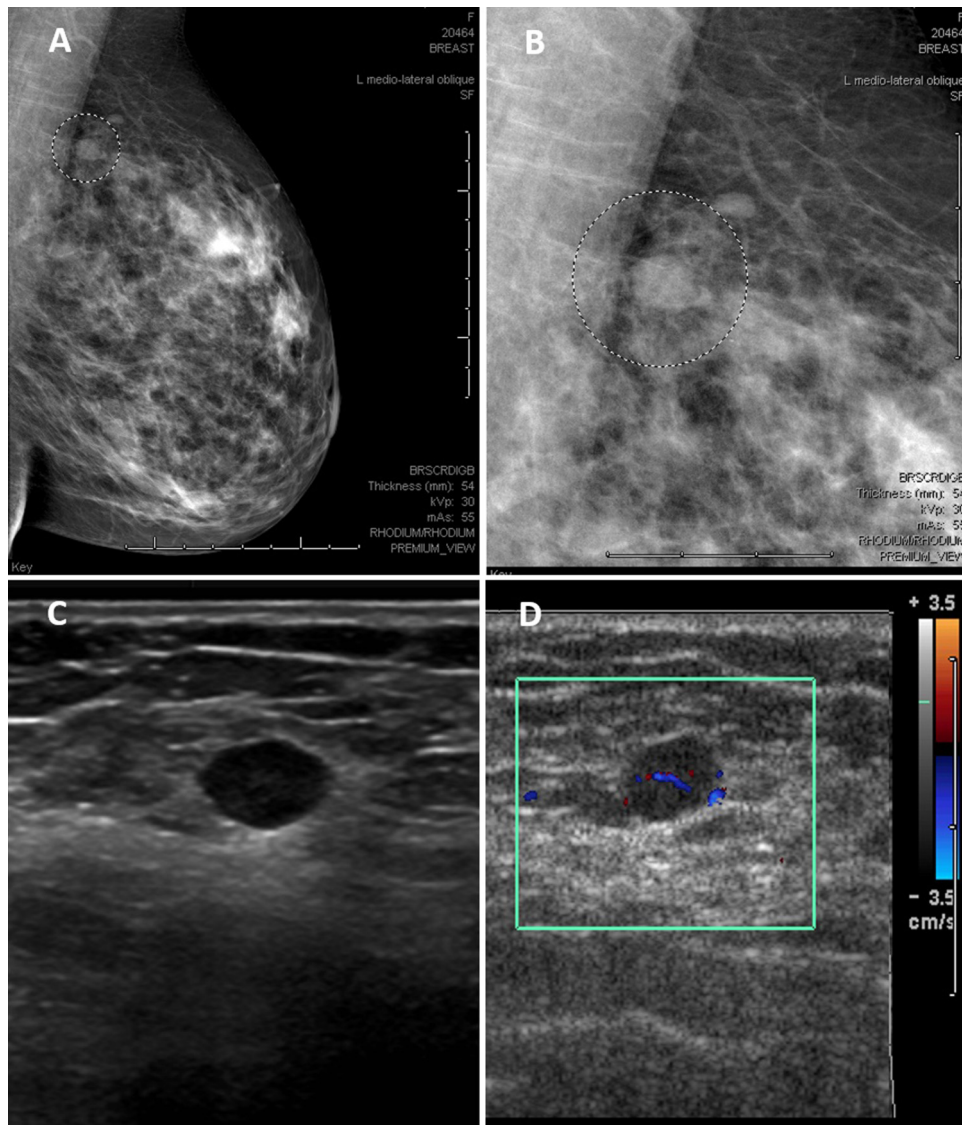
(A and B) The mammogram showing a nodular mass with well defined margins. Ultrasound showing a well circumscribed hypoechoic mass (C) with internal vascularity (D).
